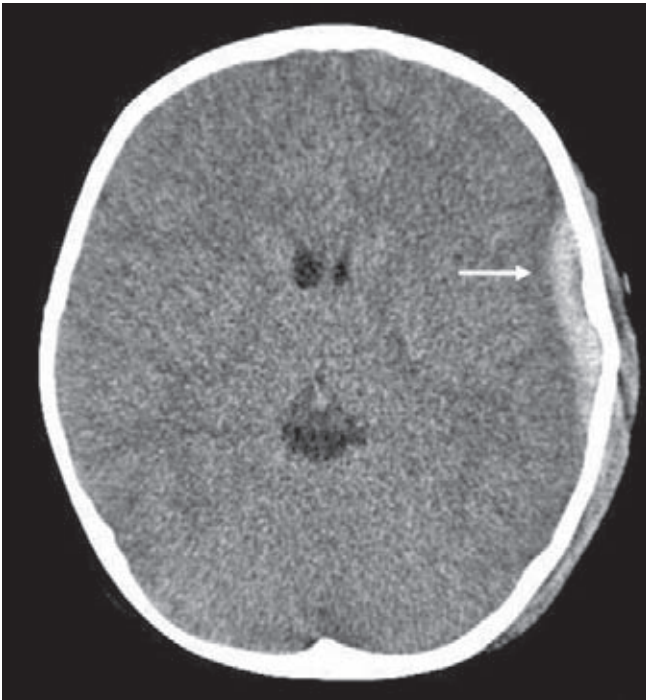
Acute left subdural haematoma. Unenhanced CT scan of brain demonstrates a crescentic collection of blood overlying the left cerebral hemisphere (arrow)
